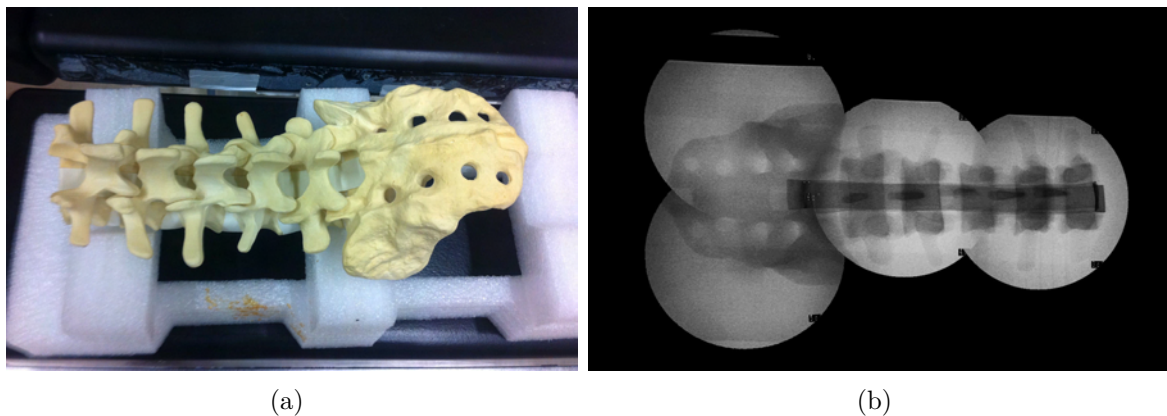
(a) A plastic lumbar and sacrum; (b) A parallax-free panoramic X-ray image of the plastic lumbar and sacrum.
